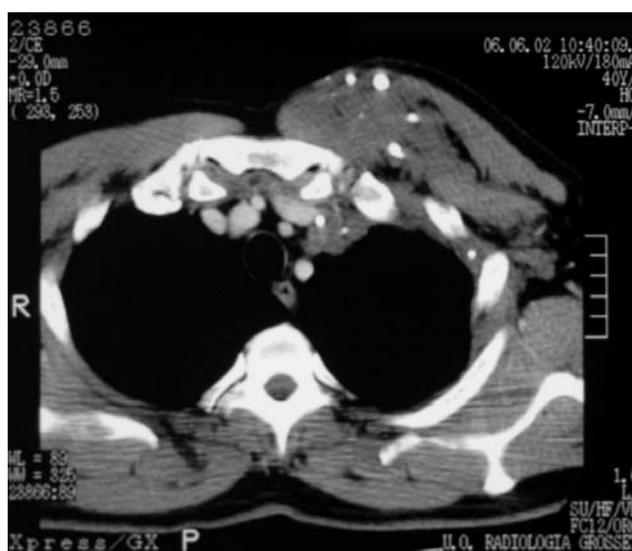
Case 3. Chest CT scan.
